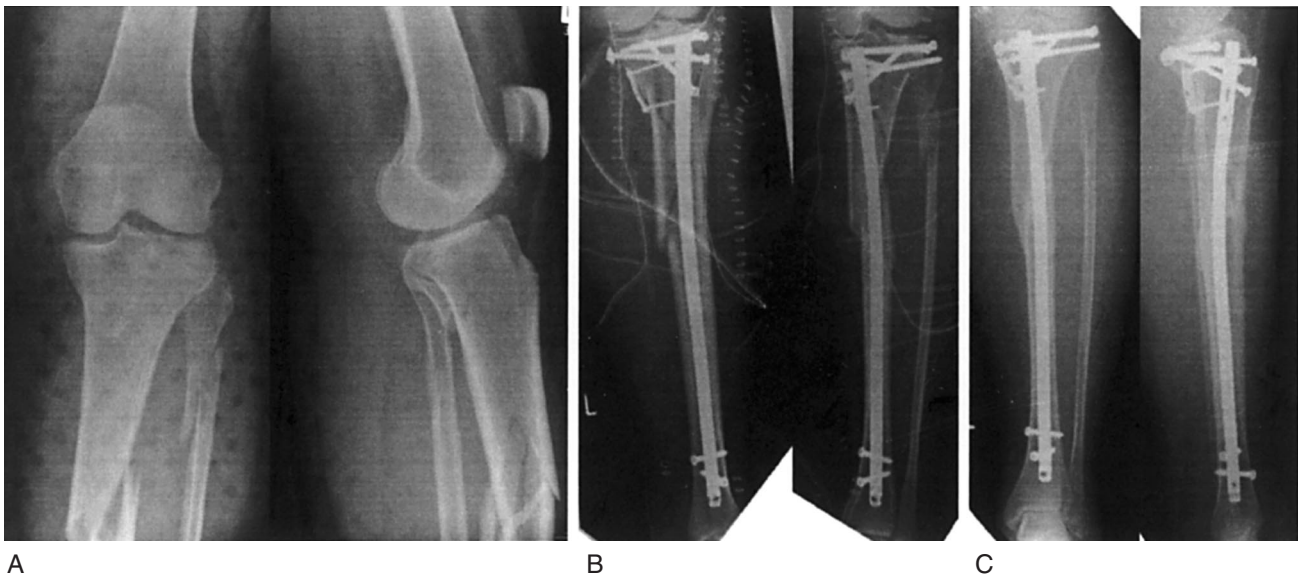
A: A 53-year old female sustained a combined intraarticular and segmental shaft fracture of the tibia (41C1 and 42C1). B: Stabilization was performed with a lag screw fixation and plate osteosynthesis for the intraarticular component and followed by intramedullary nailing with an Expert Tibial Nail for the metaphyseal-diaphyseal component. C: Radiographs at thirteen months post trauma show the healed tibial fractures in anatomical alignment. The patient has a good clinical outcome.
